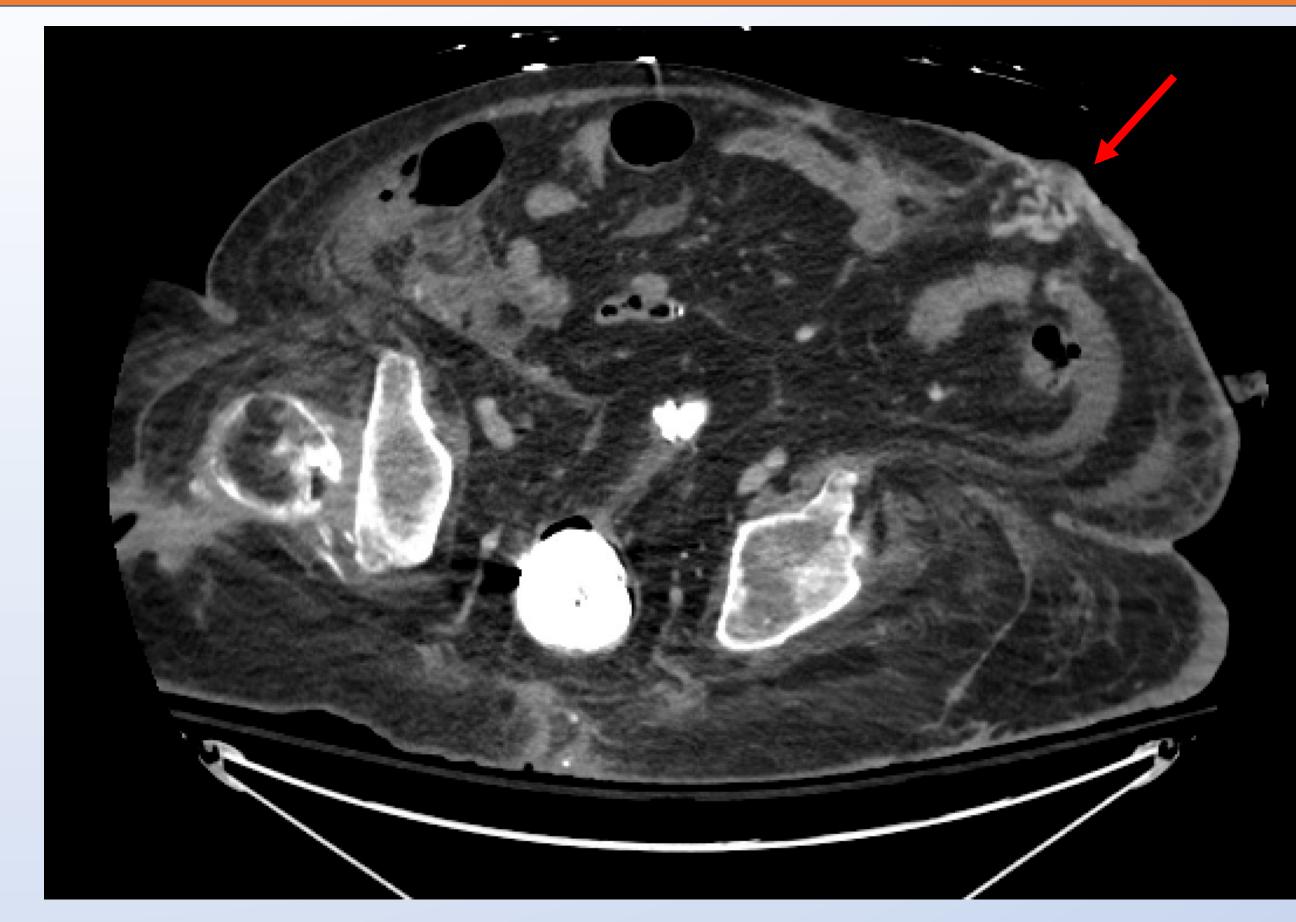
CTA showing presence of dilated parastomal vessels
